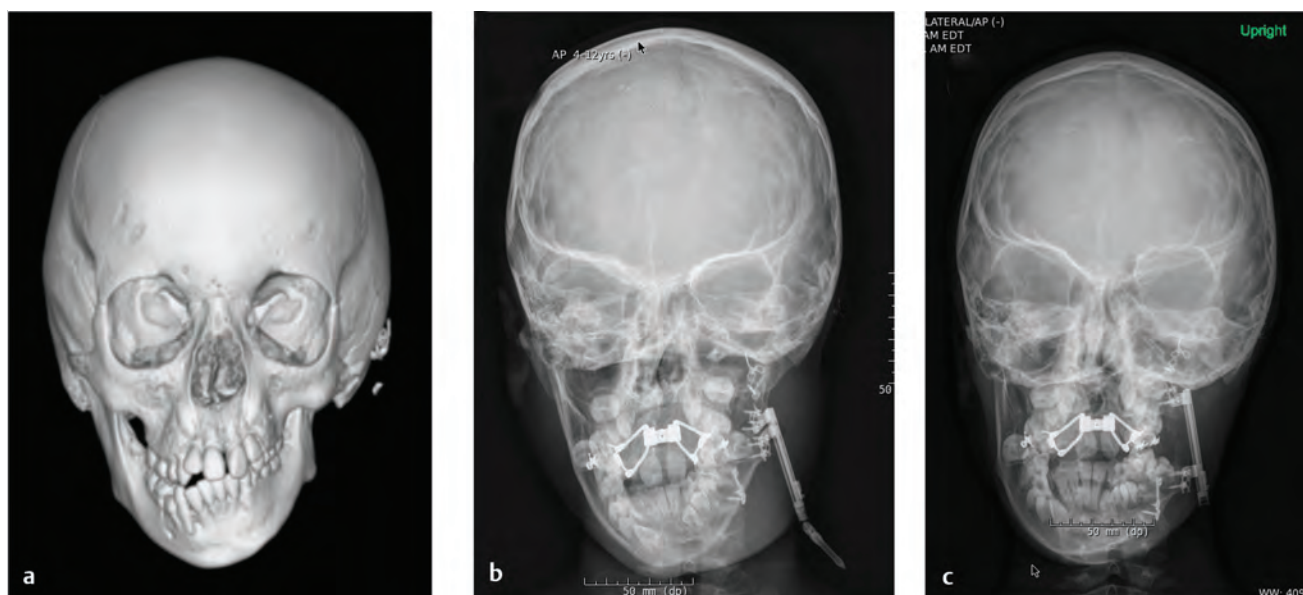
Vertical mandibular distraction for vertical mandible. (a) 3D CT scan demonstrating small left mandible with occlusal cant and vertically shortened ipsilateral maxilla. (b) Distractor in place but before distraction. (c) Full distraction of 20 mm with orthodontic closure of open bite during distraction activation phase.
